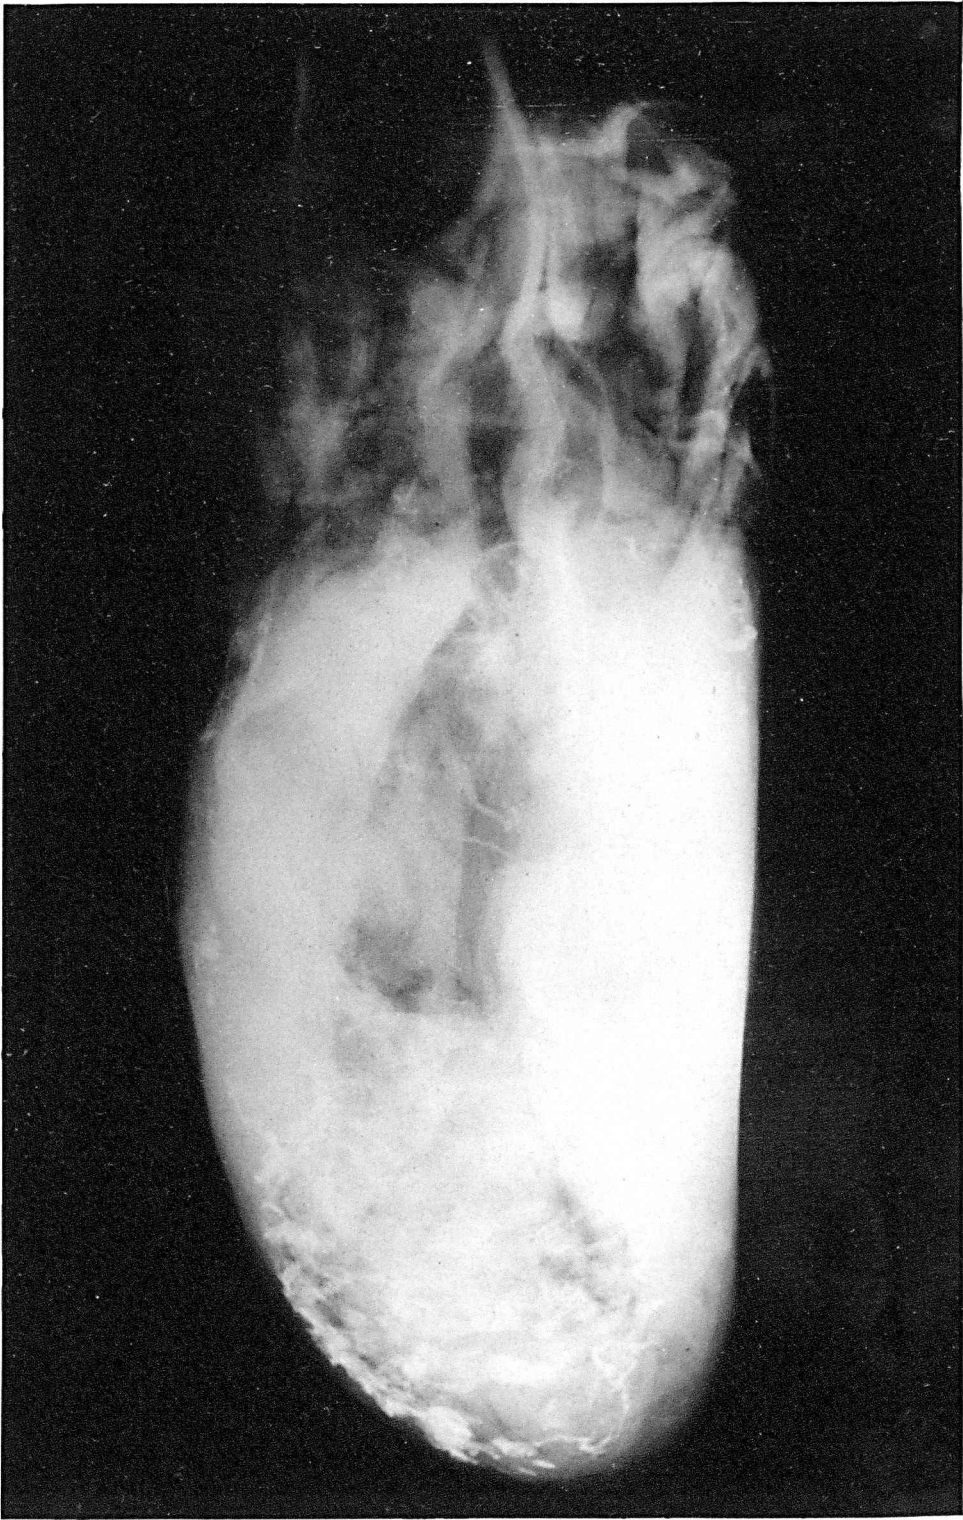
Left lateral radiograph.
